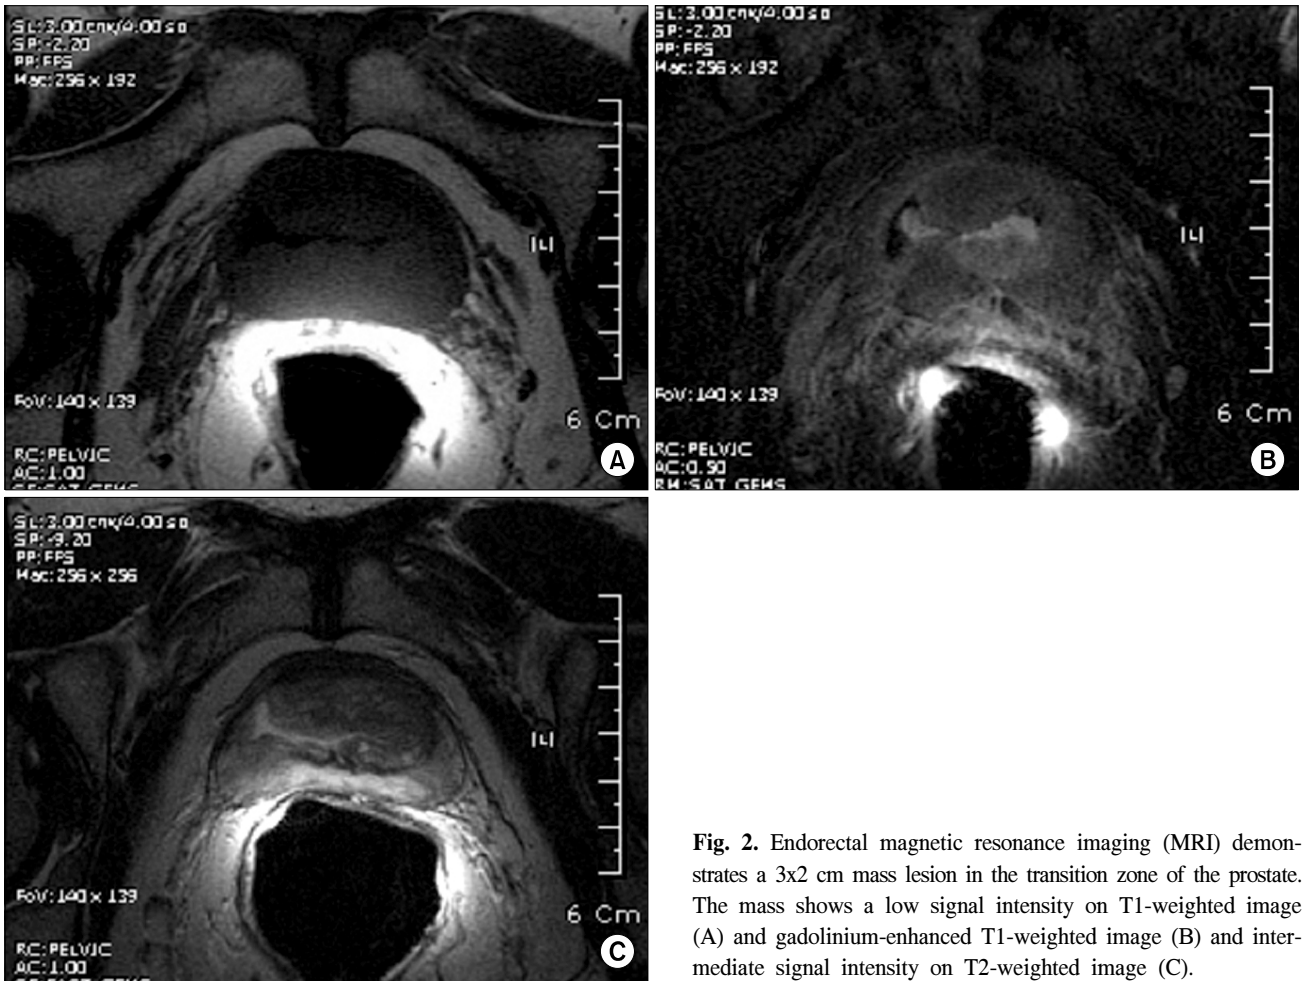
Endorectal magnetic resonance imaging (MRI) demonstrates a 3x2 cm mass lesion in the transition zone of the prostate. The mass shows a low signal intensity on T1-weighted image (A) and gadolinium-enhanced T1-weighted image (B) and intermediate signal intensity on T2-weighted image (C).
